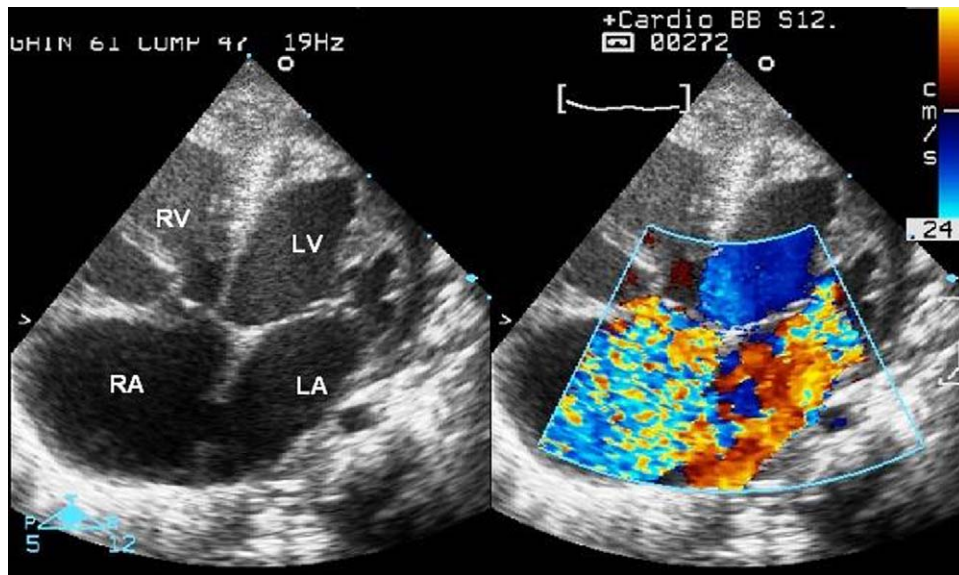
Apical four-chamber view without (left) and with colour Doppler (right). The right and left cavities are dilated massively. In systole, colour Doppler scans show severe tricuspid and mitral regurgitation. LA: left atrium; LV: left ventricle; RA: right atrium; RV: right ventricle (Supplementary data).
